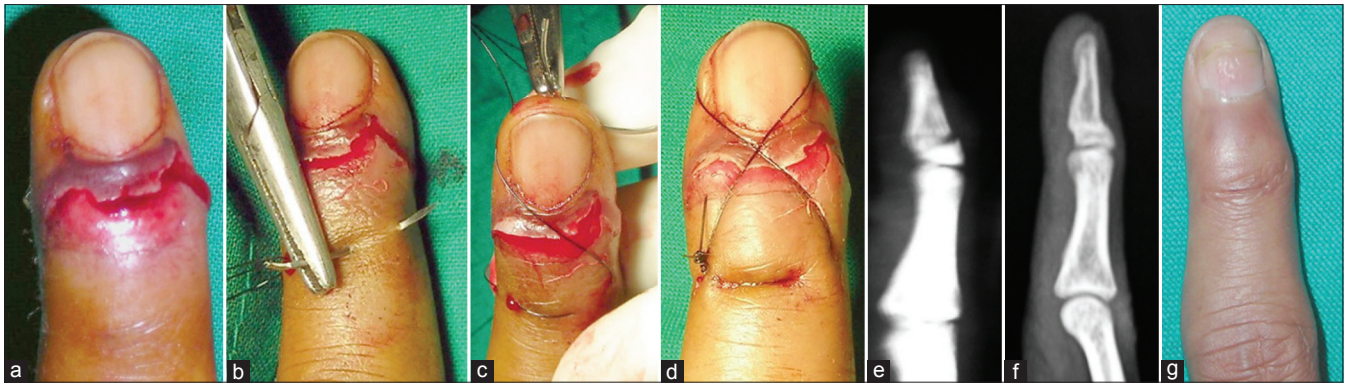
A clinical photograph (a-d and g) and X-rays (e,f) (lateral view) shows (a) Proximal nail plate avulsion with laceration of the nail fold. (b) The suture is placed transversely proximal to the wound such as to avoid injury to the germinal matrix. (c) The distal suture is taken through the tip of the finger pulp by crossing over the repositioned nail to cause vertical figure-of-eight loop. (d) Completed suture over dorsum of fingertip over the nail with adequate tension. (e and f) The fracture of distal phalanx that was reduced without formal internal fixation healed without any deformity. (g) Clinically stable fingertip at 3 months followup
